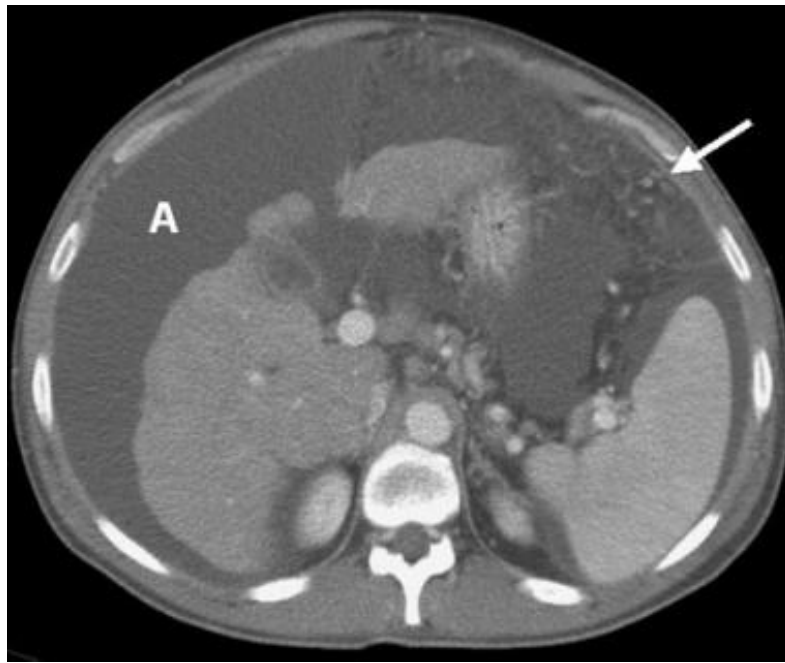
CT abdomen showing Ascites
